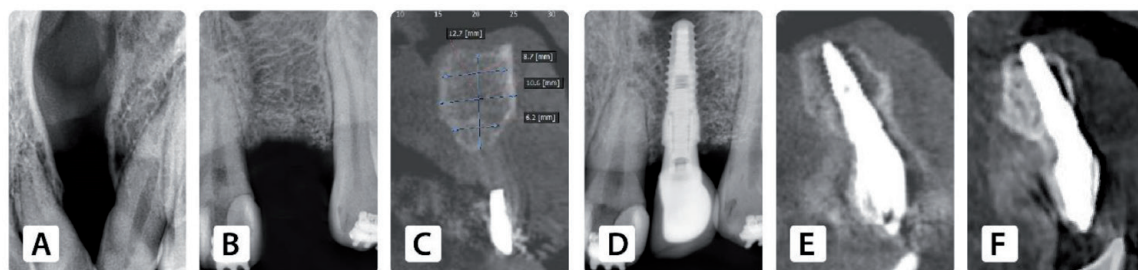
Postoperative treatment outcome on radiography (A) clinical alveolar cleft. (B) Bone formation after alveolar bone grafting. (C) Bone volume before implant placement. (D) Dental implant placement on periapical radiography. (E) Dental implant placement on CBCT. (F) Dental implant after 96 months' follow-up on CBCT.
